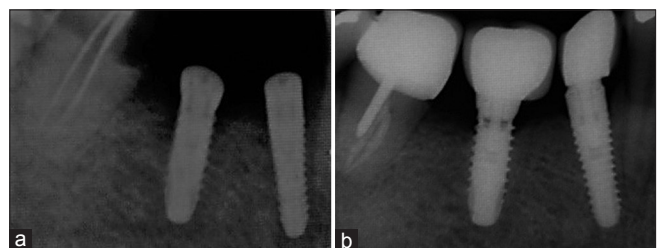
Radiographic image of cylindrical implants (a) at the baseline and (b) 6 months later
